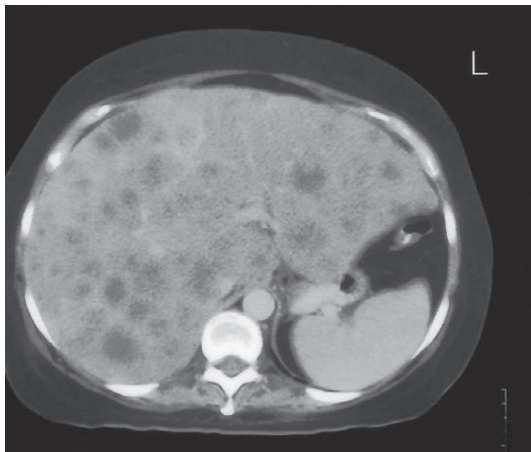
CT scan of abdomen. Numerous liver metastases are seen in both the right and left lobes of the liver.
